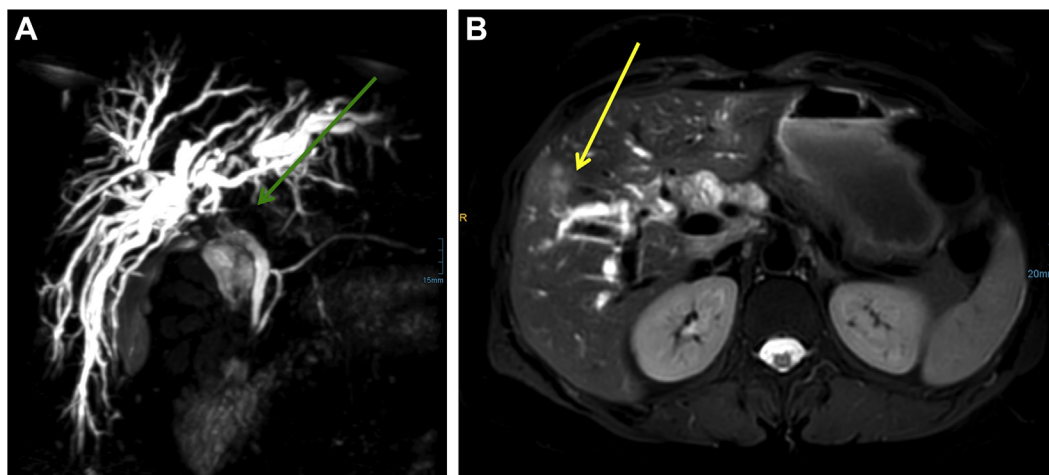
Magnetic resonance images of intrahepatic biliary dilatation (green arrow) (A) and irregular hepatic lesions which are hyperintensive on T2-weighted images (yellow arrow) (B).
